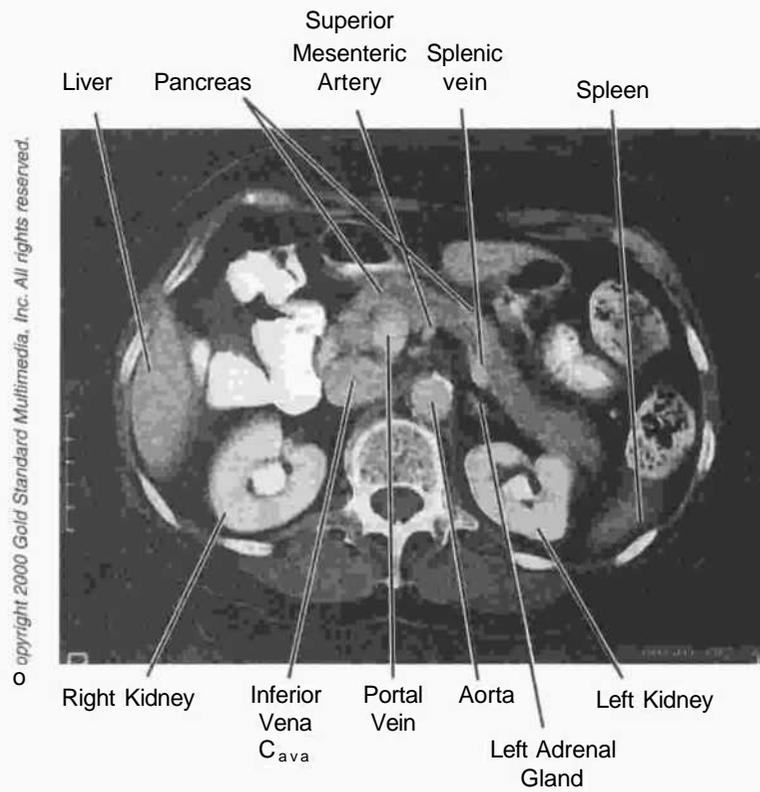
Figure IH-3-40. Abdomen: CT, Li
